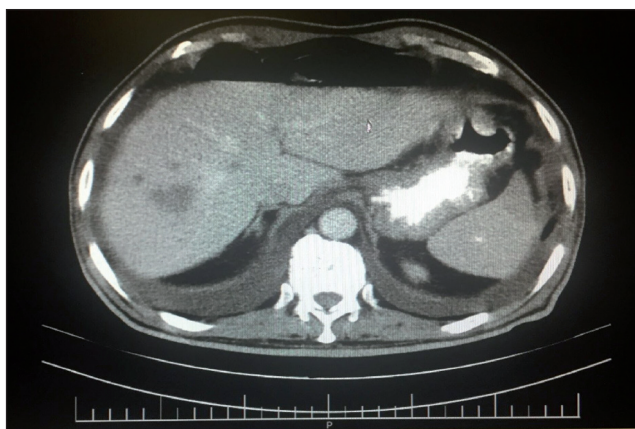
Abdominal and pelvic CT showed multiple hypodense lesions in liver compatible with metastasis and pleural effusion.
